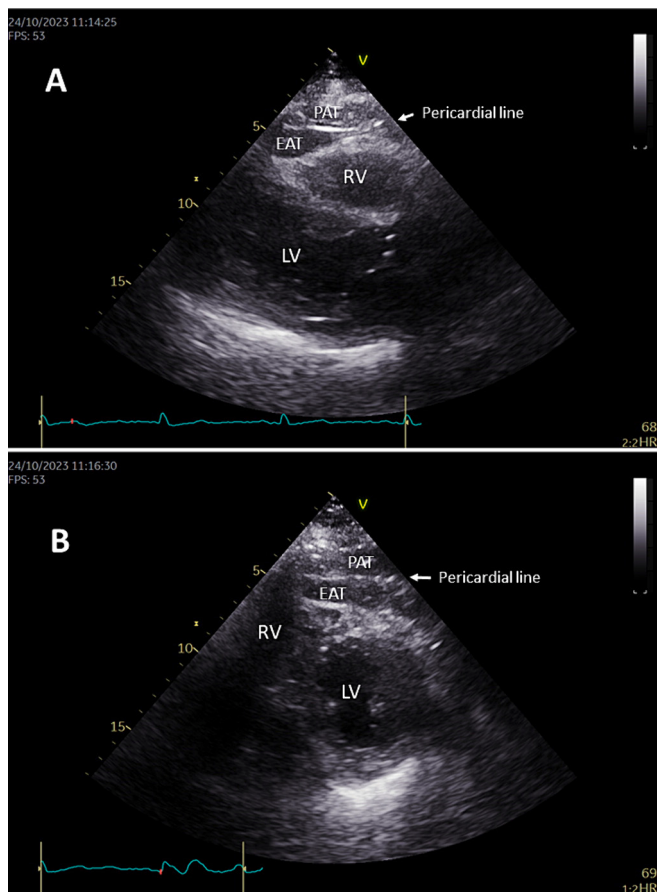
Quantification of the Epicardial Adipose Tissue by Echocardiography. Images were obtained from the left-parasternal acoustic window in long-axis (A) and short-axis (B). Epicardial thickness can be measured in any of those windows. Pericardium line is detected and epicardial and paracardial adipose tissue can be distinguished. EAT – epicardial adipose tissue; PAD – paracardial adipose tissue; LV – left ventricle; RV – right ventricle.
